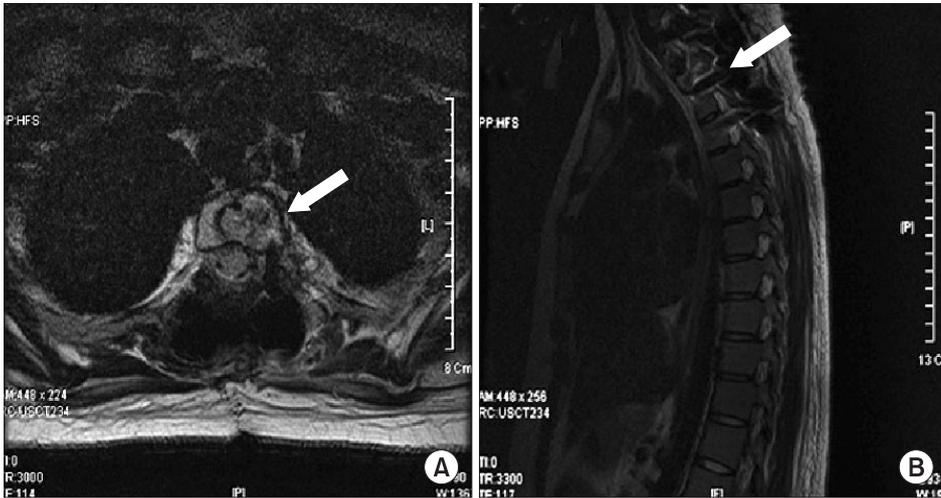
Magnetic resonance imaging of the operative site (arrow), 15 days after operation. (A) T2 axial view, (B) T2 sagittal view.
